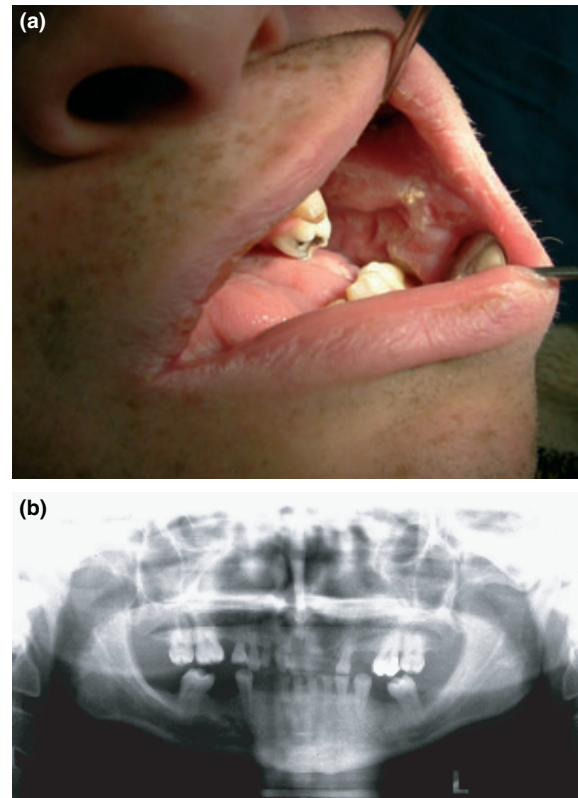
Oral findings; irregular white patches were present on the buccal mucosa (a) and panoramic radiograph showing the present status of dentition included twelve primary teeth, six permanent teeth (b).
